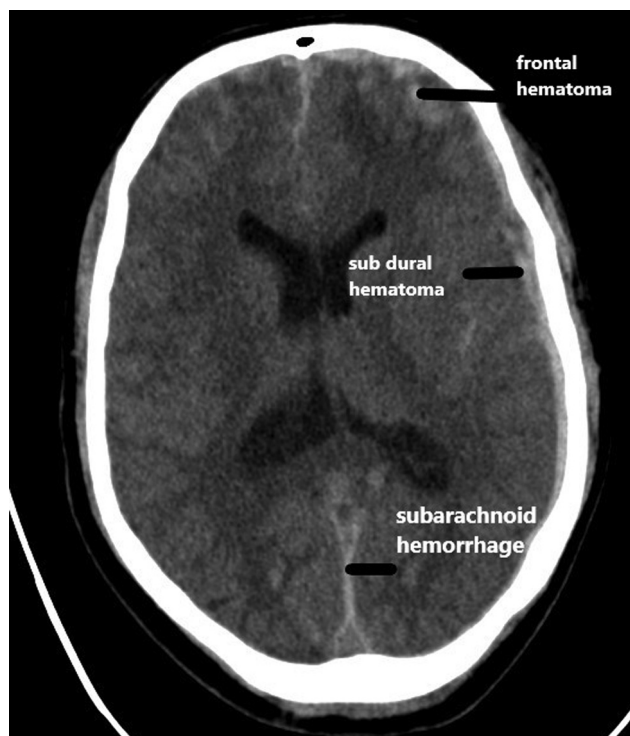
Computed tomography scan of head on admission showing left-side frontal hematoma with thin subdural and subarachnoid hemorrhage.
